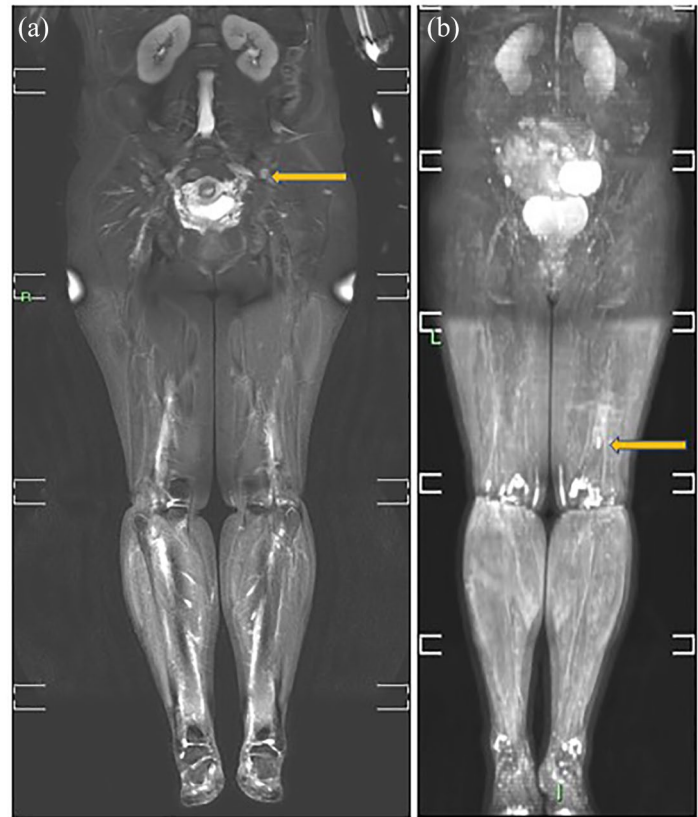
Whole-body MRI performed at 25 weeks of pregnancy. (a) 17 × 13 mm focal lesion in the left ileum wing, and tiny lesions in the ileum bones; (b) heterogeneous bone marrow along the thighs which is particularly pronounced in the right distal thigh.
